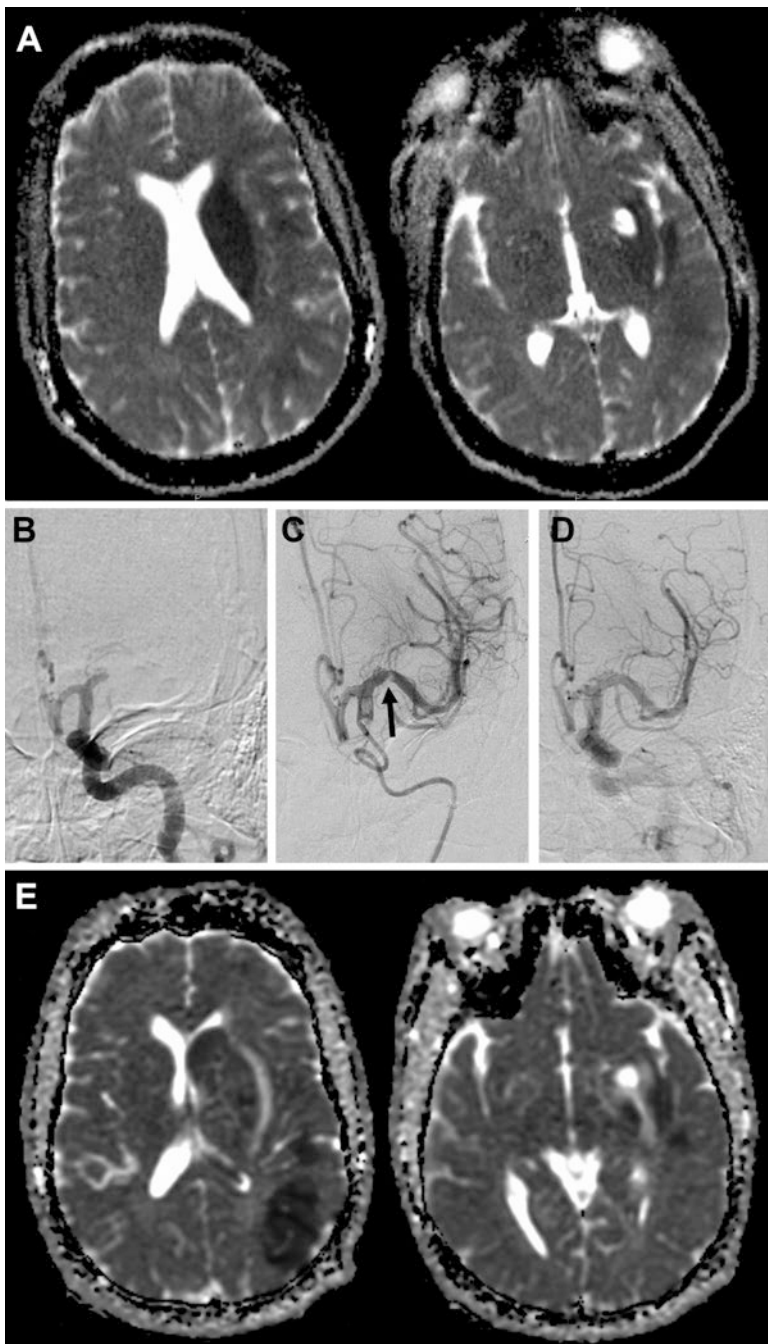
Treatment course of a 37-year-old man who awoke with a complete left MCA syndrome and presented with an NIHSS score of 21. (a) Initial MRI showed small core infarct size with large symptomatic penumbra. (b) Pretreatment angiogram revealed an occlusive proximal left M1 thrombus. (c) Saddle embolus (*arrow*) is noted on angiogram at an early MCA bifurcation after using a Penumbra Max ADAPT technique. (d) Next the SOLUMBRA technique with a combination of the Penumbra Max thromboaspiration catheter and Solitaire stentriever resolved the occlusive embolus. mTICI 2b reperfusion was achieved, as a small portion of the clot embolized
